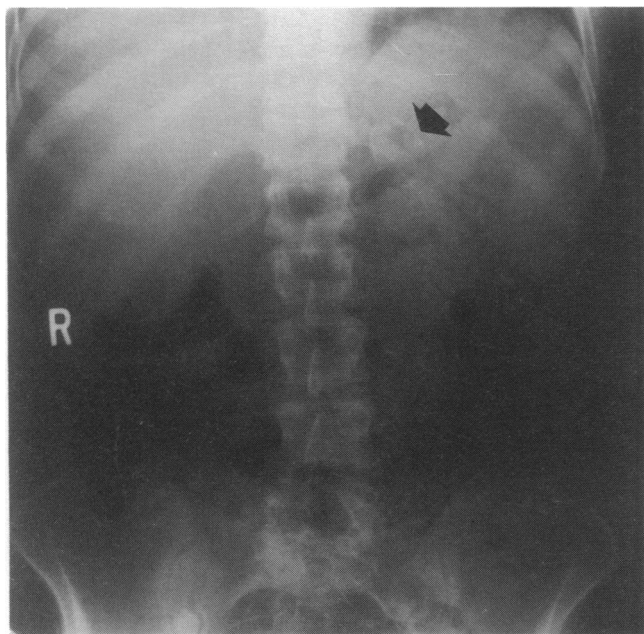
Plain radiograph showing the typical signet ring calcification of a splenic artery aneurysm.
